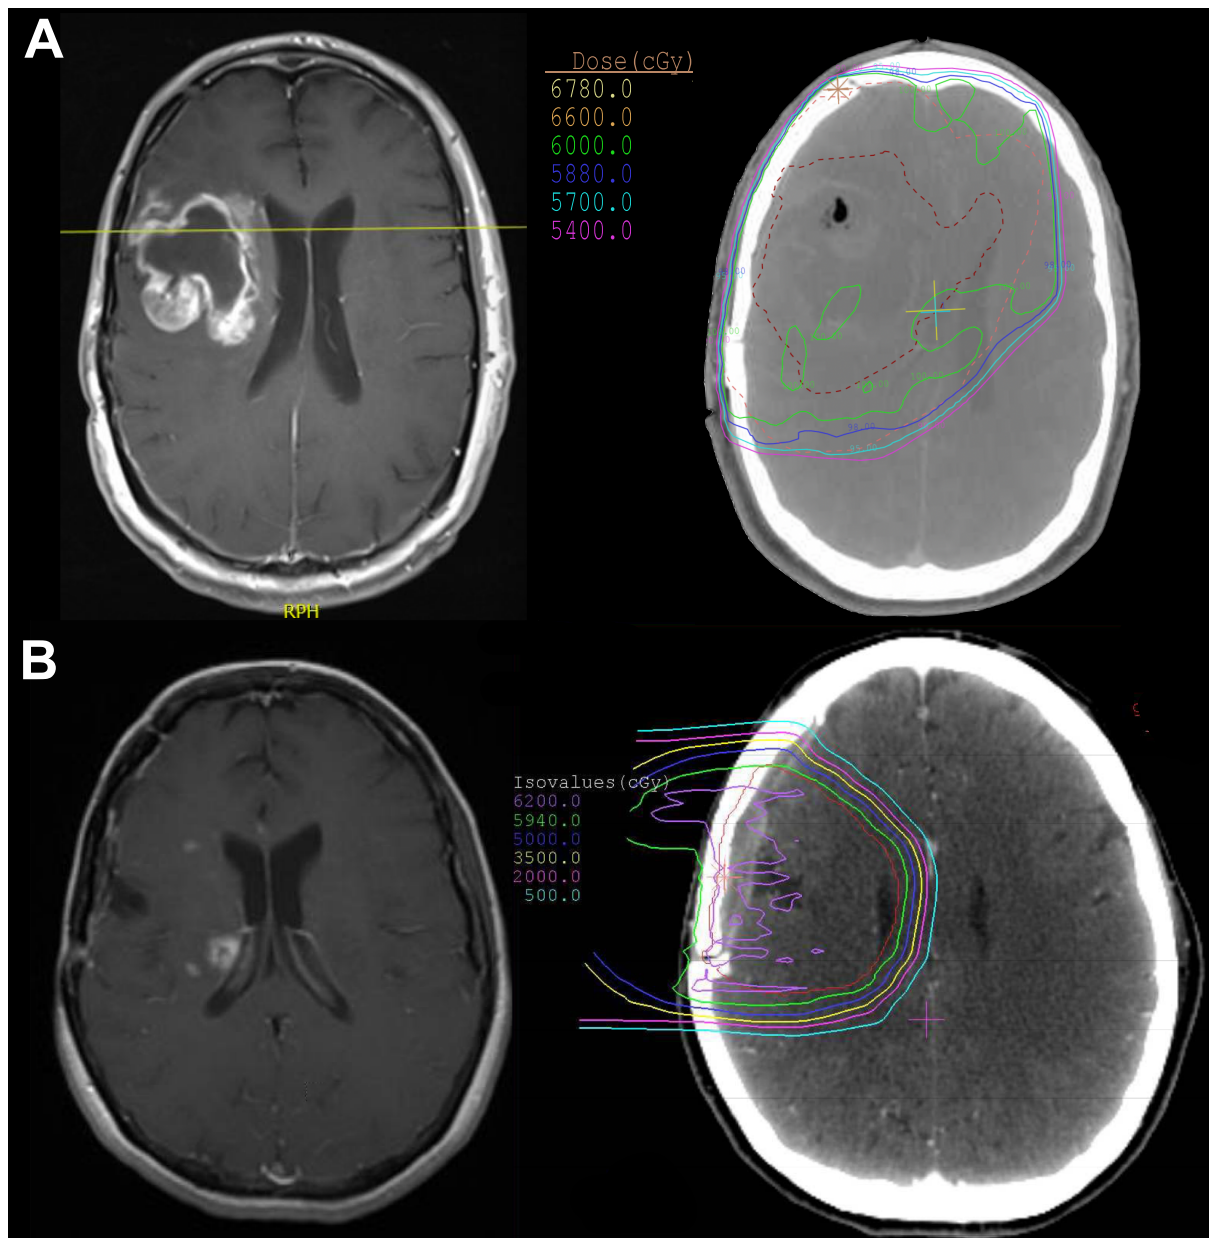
Typical radiographic features of PP and TN.
